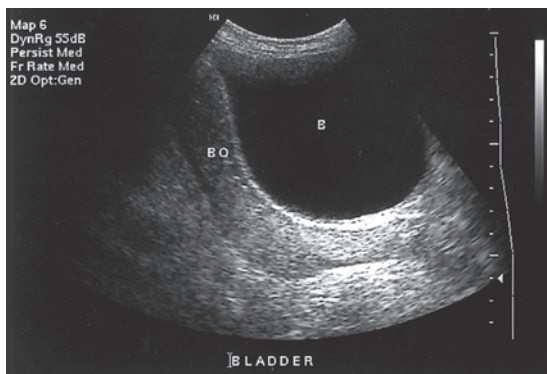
Bowel loop mimicking the uterus after hysterectomy. Longitudinal sonogram in a posthysterectomy patient demonstrating a bowel loop (BO) in the uterine space. Although this appearance can mimic a uterus, note that the endometrial echo is not demonstrated. Bladder (B).
